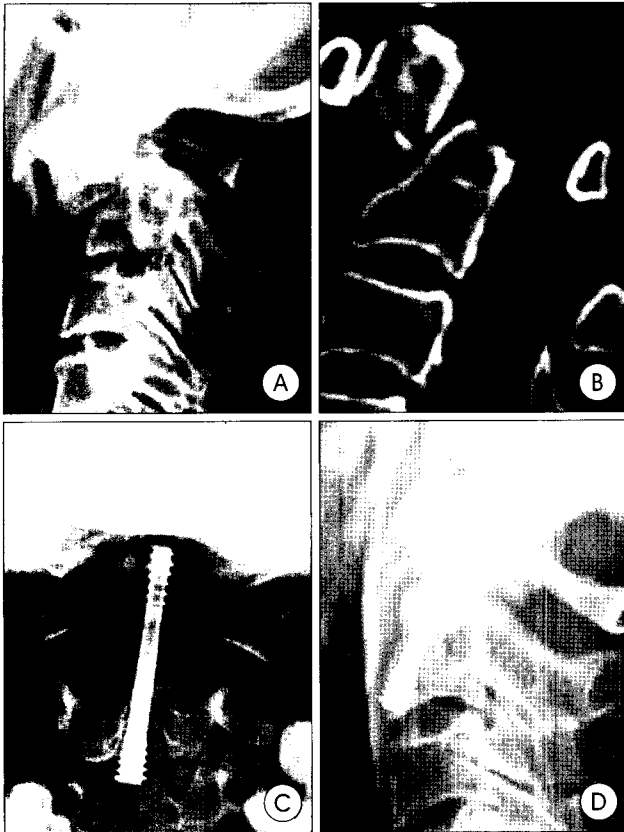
A 4.5mm cannulated Herbert screw is used in anterior screw fixation of type II odontoid process fracture. Preoperative lateral view of plain cervical X-ray(A) and Sagittal reconstruction view of computed tomography(B) showing severe anterior displacement of fractured odontoid process with a horizontal fracture line. Postoperative open-mouth(C) and lateral view(D) showing excellent anterior odontoid fixation.
